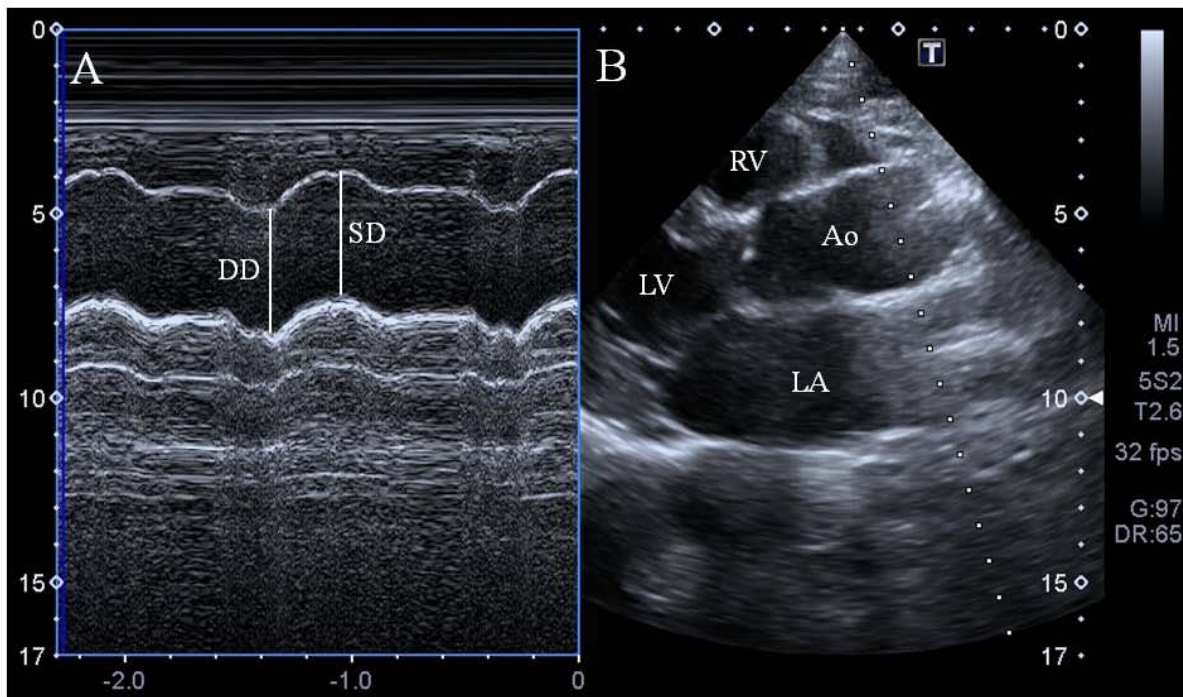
Measurements of systolic (SD) and diastolic (DD) diameters of the ascending aorta (A) are shown on the M-mode tracing obtained at a level 3 cm above the aortic valve (B) at parasternal long-axis view.
